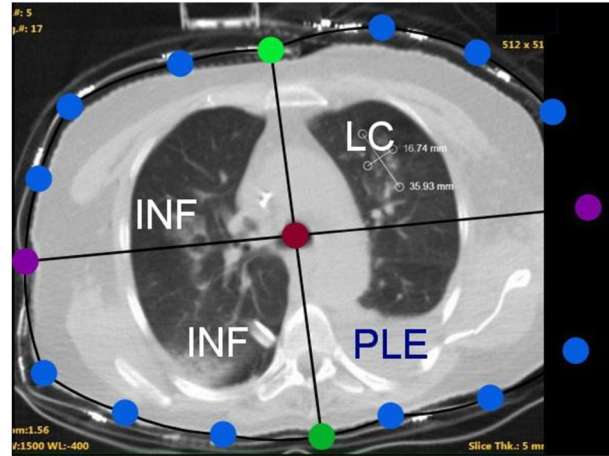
The fem-mesh over imposing on to the CT scan.
